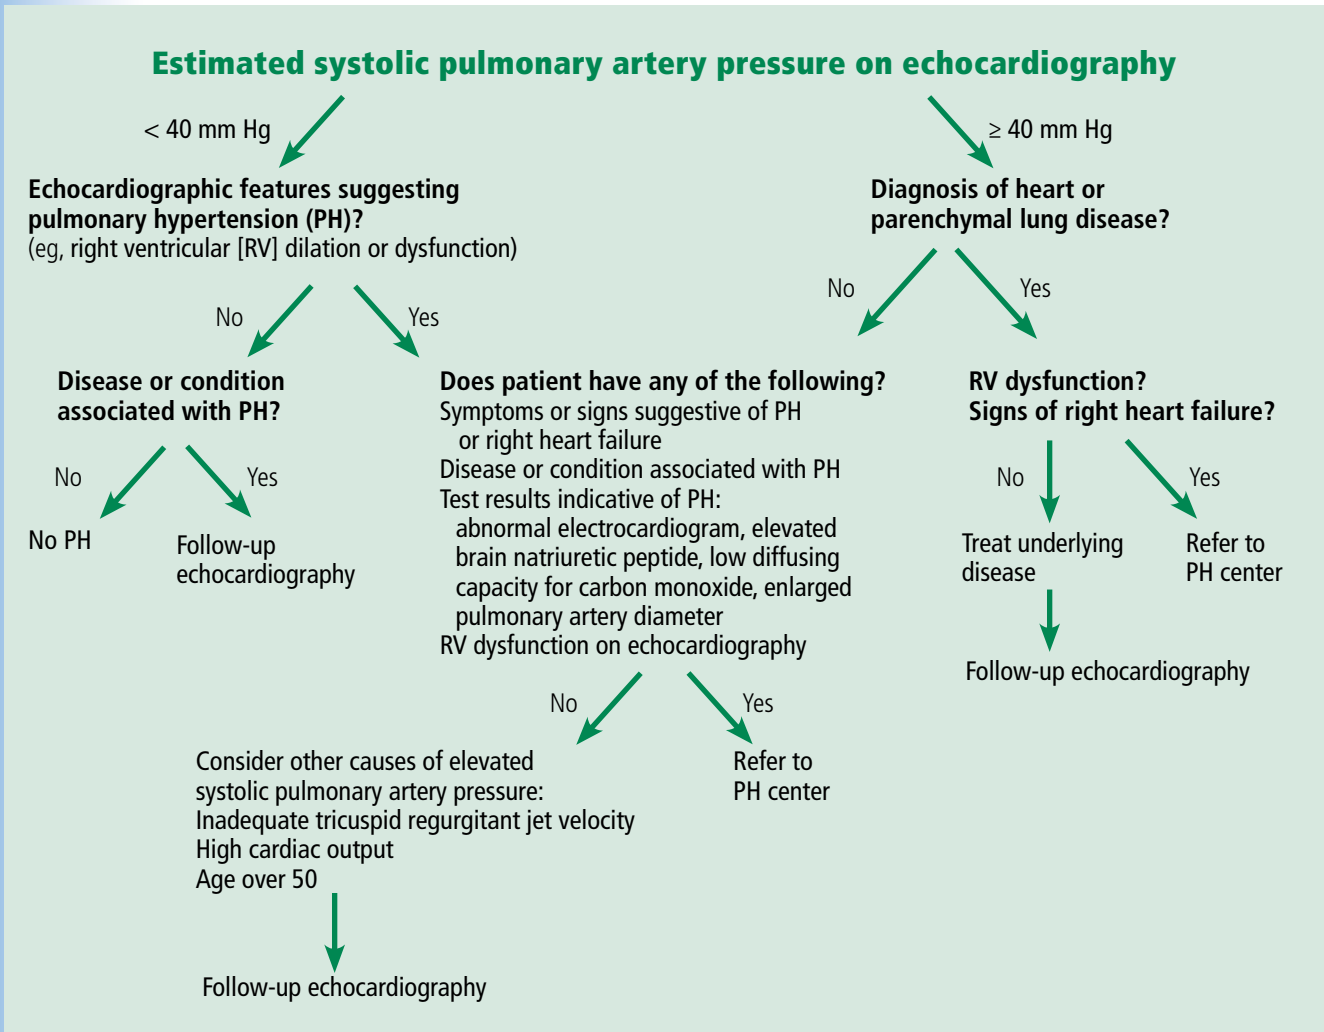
An algorithmic approach to the assessment of systolic pulmonary artery pressure on echocardiography.
